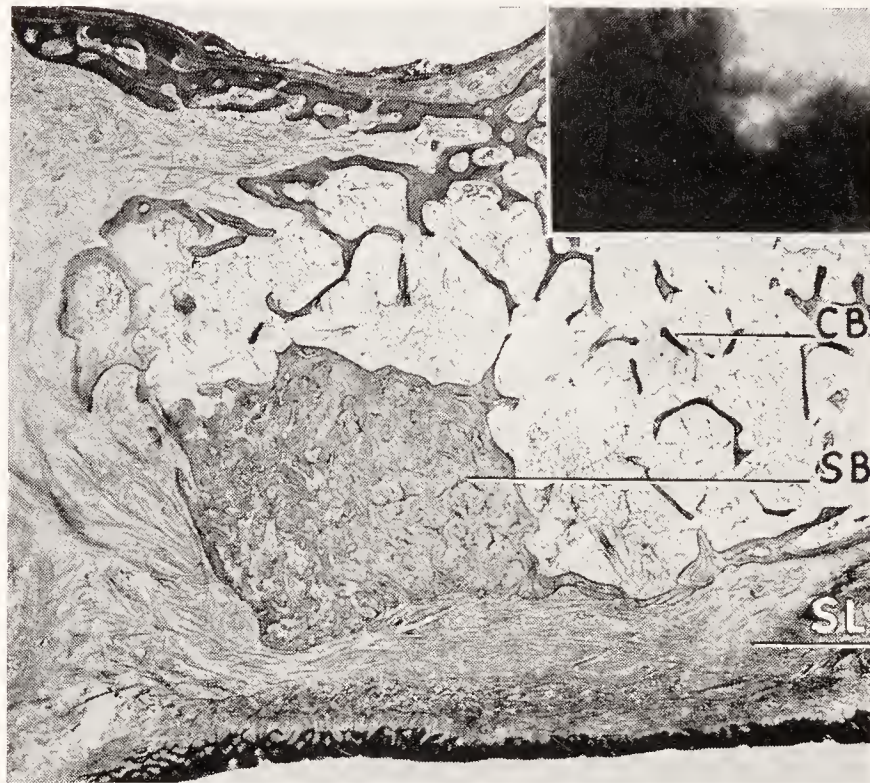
Mesio-distal section through an edentulous maxilla. The radiograph in the right upper corner shows a distinctly outlined radiopaque area in the posterior portion of the maxilla. *SL*, soft tissue lining of the edentulous maxilla; *CB*, cancellous bone of the maxilla; *SB*, area of compact bone lying next to the surface of the bone.
